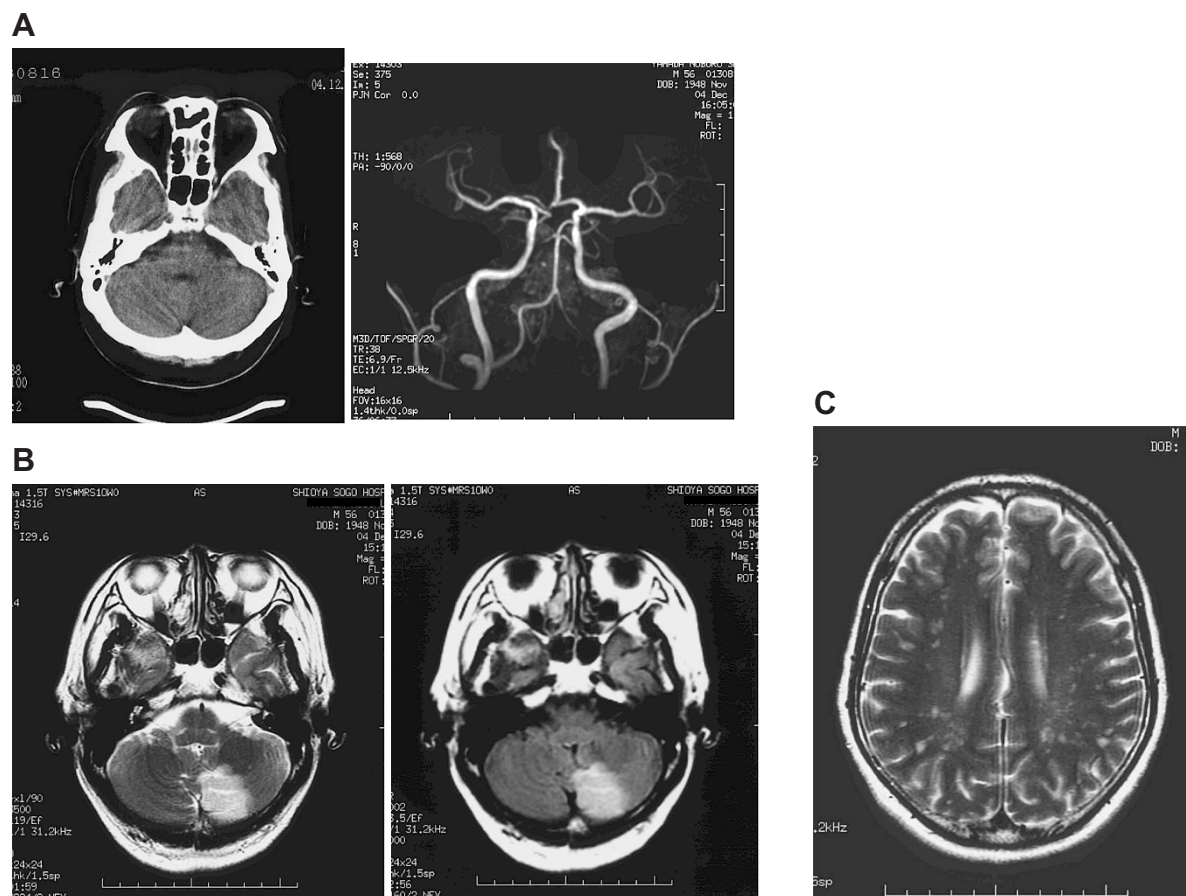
A: Brain CT (left panel) and MR angiogram (right panel) on admission, showing no abnormalities. B: T₂-weighted imaging (left panel) and FLAIR imaging (right panel) of MRI on December 20 demonstrated an area of high intensity in the left cerebellar hemisphere. C: T₂-weighted imaging of deep white matter lesion. There was no silent cerebral infarction or periventricular hyperintensity, but there were several hyper-intense punctuates in the deep white matter.
